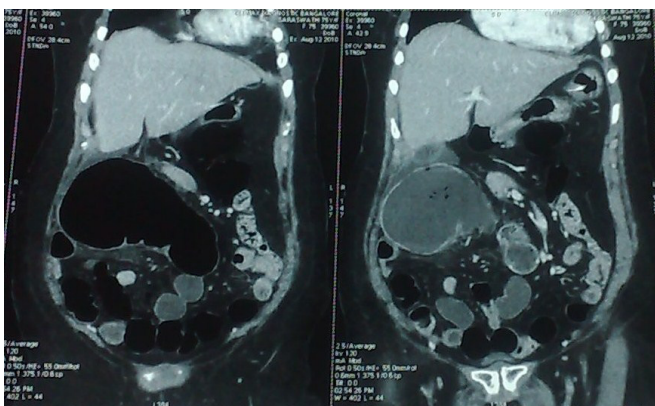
CT abdomen and pelvis showing massively dilated caecum with associated small bowel dilation
